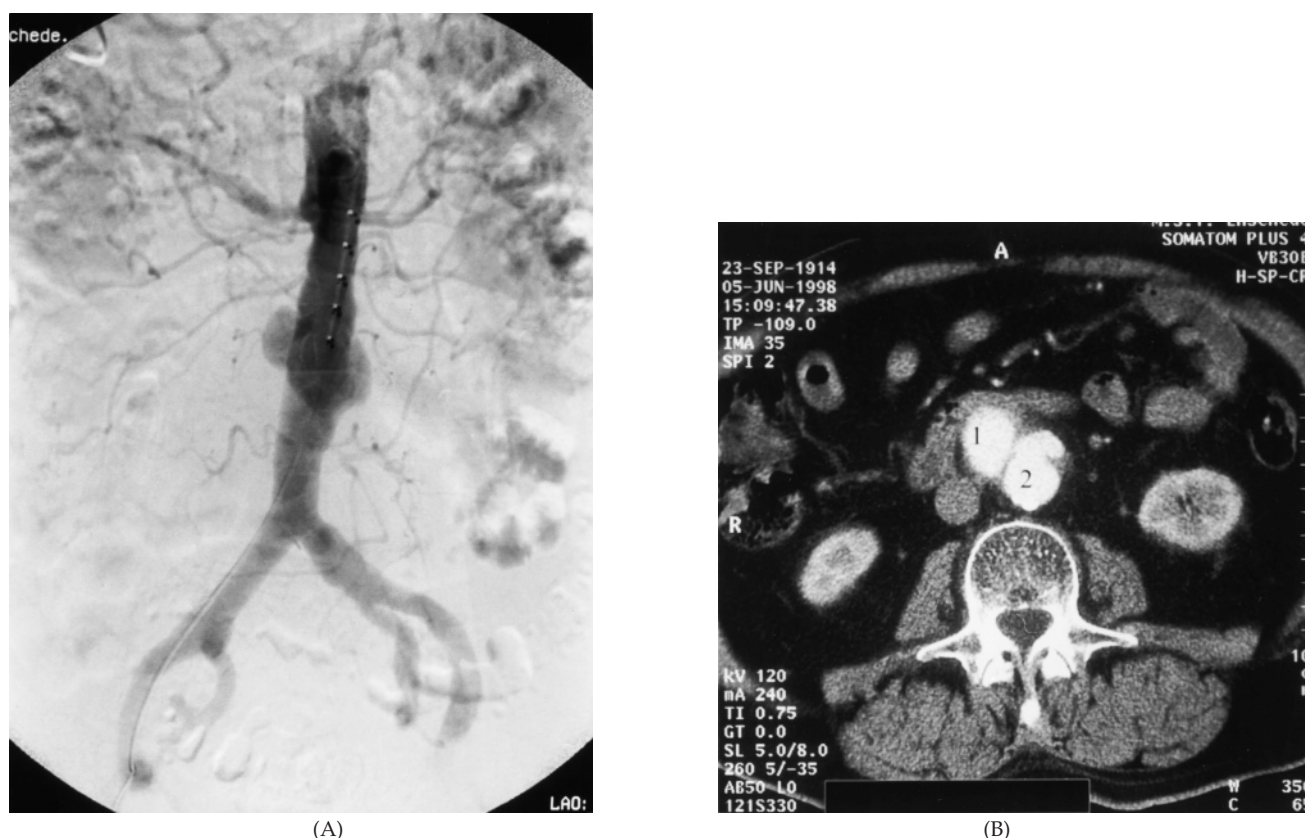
(A) Preoperative intra-arterial abdominal angiography demonstrating the saccular aneurysm. (B) Preoperative spiral CT scan. 1 = aorta; 2 = saccular aneurysm.
